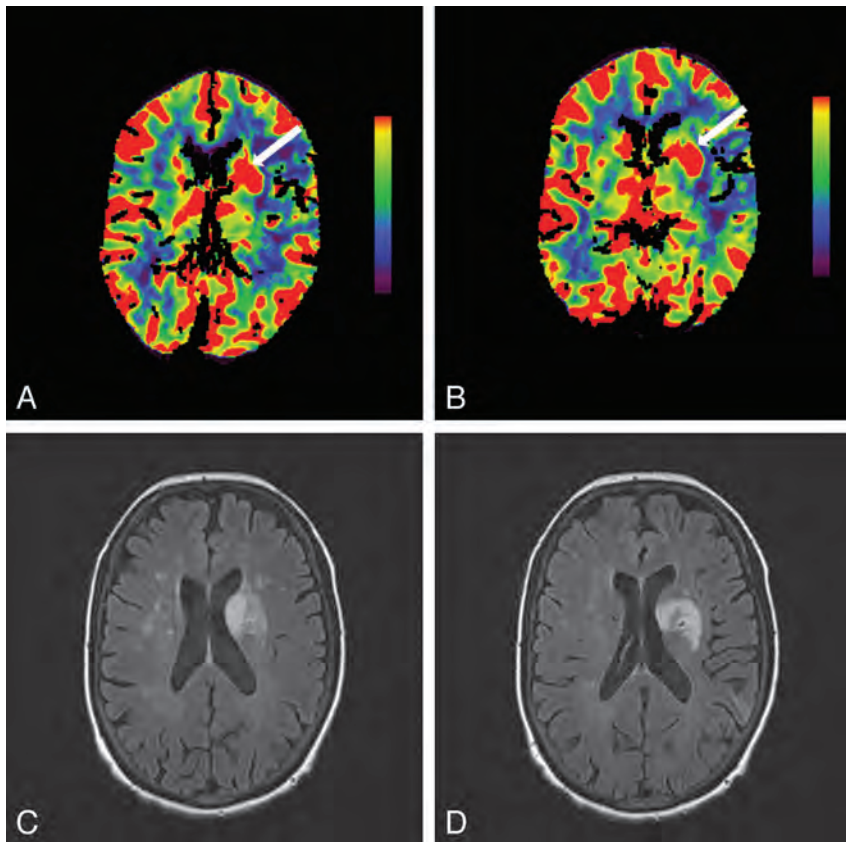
Hyperperfusion of the left basal ganglia is shown by increased cerebral blood flow (arrow, A) and increased cerebral blood volume (arrow, B) on CT perfusion. Follow-up FLAIR MR imaging 3.5 days later shows regions of T2 hyperintensity indicating infarction of this same region (C and D).
